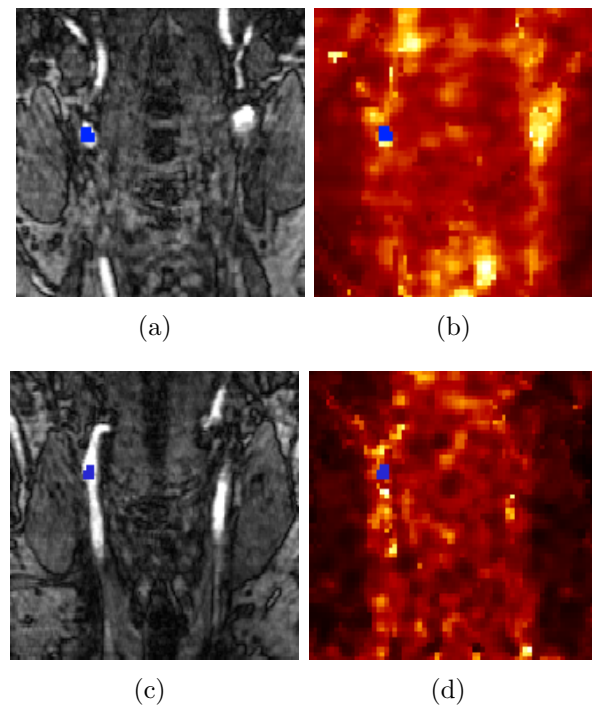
Regions of interest (ROI) chosen for the patient study: (a) ROI shown on the MR image for the 300 s acquisition, (b) ROI shown on the PET image for the 300 s acquisition, (c) ROI shown on the MR image for the 30 s acquisition, (d) ROI shown on the PET image for the 30 s acquisition. The PET image is obtained with HKEM.
